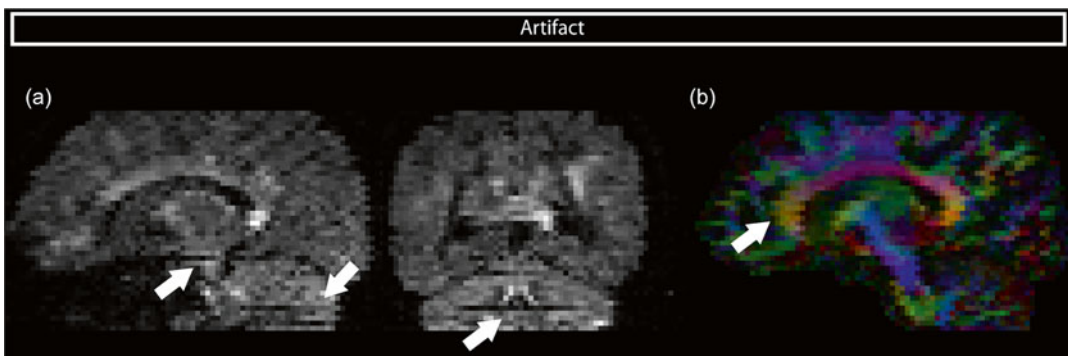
(a) Interslice instabilities might not be visible on the axially interleaved acquisition plane, but becomes visible on the orthogonal planes in a DWI volume. (b) DEC map with interleave artifact
